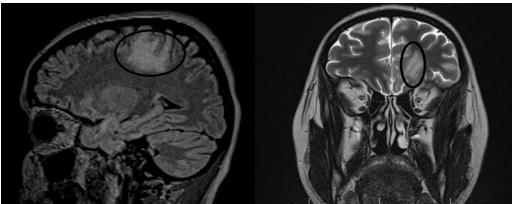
MRI exam distinguish T2 and FLAIR hypersignal areas. Lesions are localized supratentorial, bilaterally, asymmetric – sagittal and coronal slices
